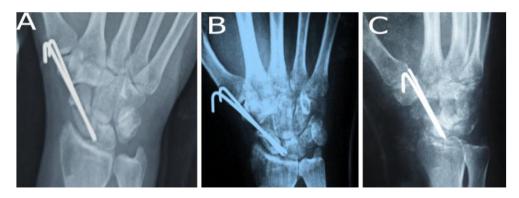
PA radiograph early after the grafting procedure, (B and C) radiograph 10 weeks after the grafting procedure.
